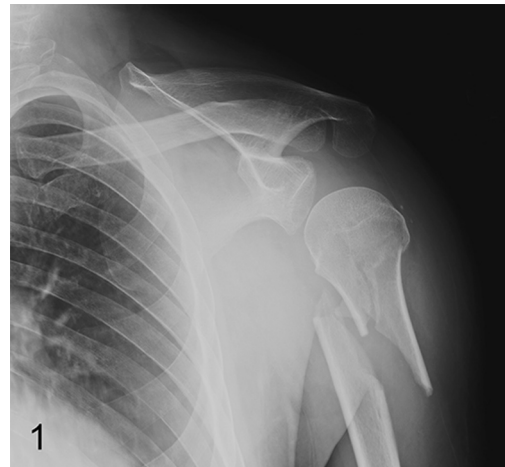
AP radiograph of the left shoulder demonstrates a comminuted fracture of the left proximal humerus with medial displacement. This was the patient's original injury.
